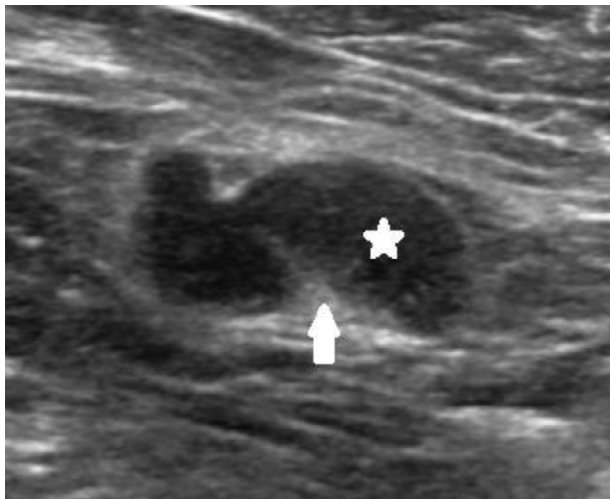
Diagnostic axillary ultrasound from September 2020 demonstrates a suspicious right axillary lymph node with a thickened cortex (star) and a diminutive, thinned hilum (arrow).
